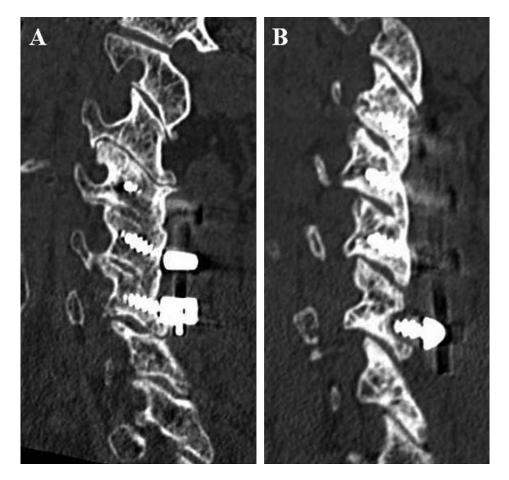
(A) CT showing bony facet fusion at C4/5/6. (B) CT showing bony facet fusion at C3/4/5. Bony non-union of facet at C5/6 and a radiolucency of more than 1 mm around C6 screw are demonstrated. CT: computed tomography.
